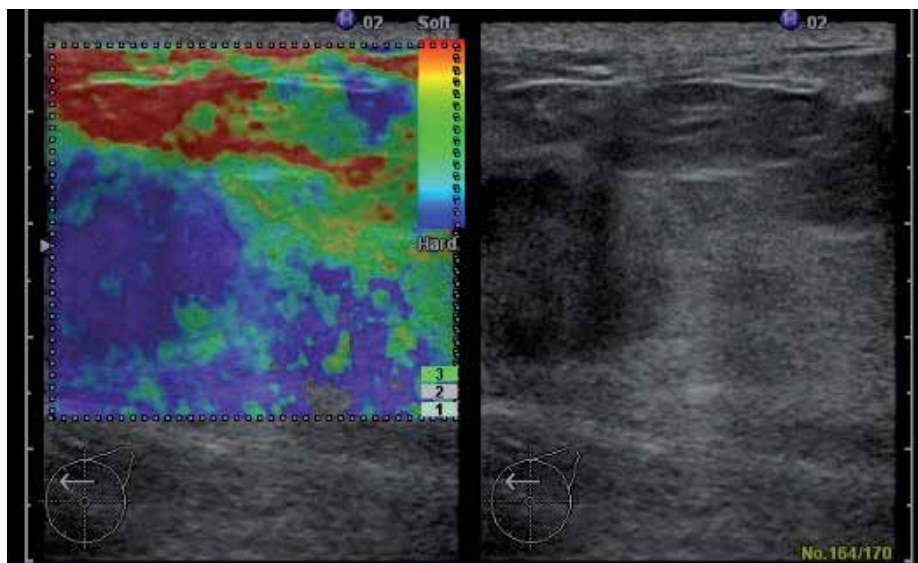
A first representative case of IDC, Ultrasound; elastography.
